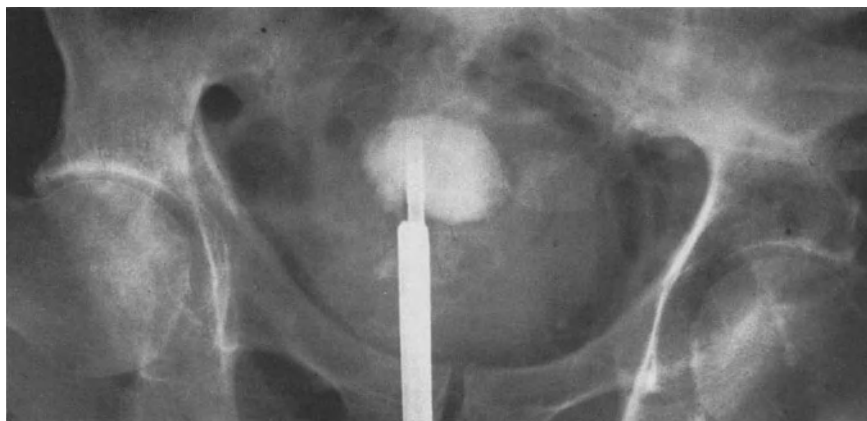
Pelvic X-ray of a 62 year old patient. The ultrasound probe has been advanced up to a stone. In the course of the procedure contact with the calculus is maintained by progressively extending the drill out of the sheath
